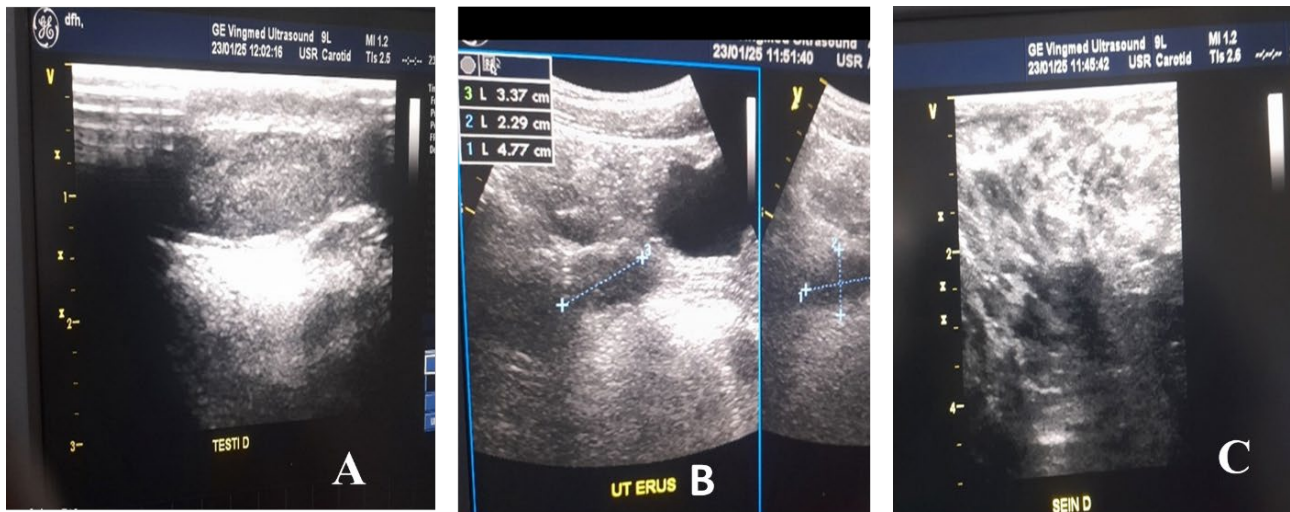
Abdominopelvic ultrasound showing the single testicle (A) and the small uterus (B) and a grammatical ultrasound (C) showing mammary glands without nodules.
